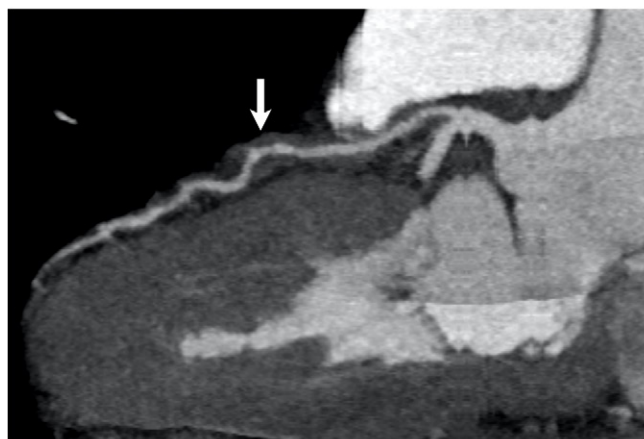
(a) Curved planar reformatted and (b) minimum intensity projection short-axis coronary CT angiography images in a 68-year-old woman, who presented with chest pain, show luminal occlusion of posterior left ventricular branch (arrow in a) with myocardial hypoperfusion in the corresponding territory (arrows in b). Involvement of single coronary artery territory and absence of an embolic source favored diagnosis of spontaneous coronary artery dissection over coronary artery embolism.
